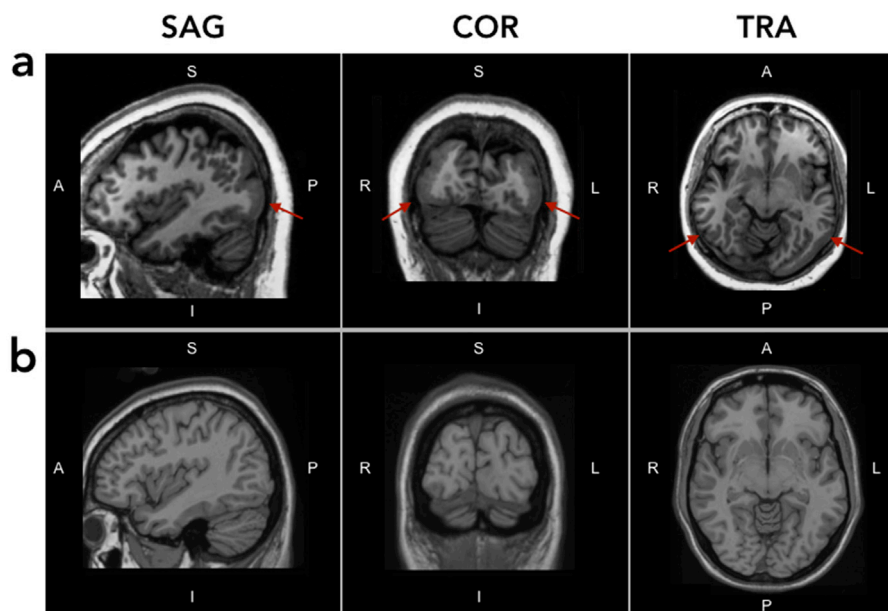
T1-weighted images of (a) the patient's brain and (b) corresponding views of the Colin brain (Holmes et al., 1998). Depicted from left to right: sagittal, coronal, and transversal views. L: left, R: right, A: anterior, P: posterior, S: superior, I: inferior.
